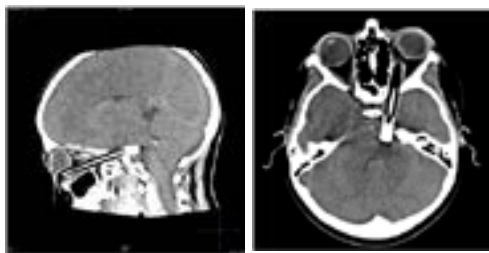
a, b: Computer Tomography (CT) scan section showing the presence of an entire pencil that crossed from the left orbital fossa into the brain.
